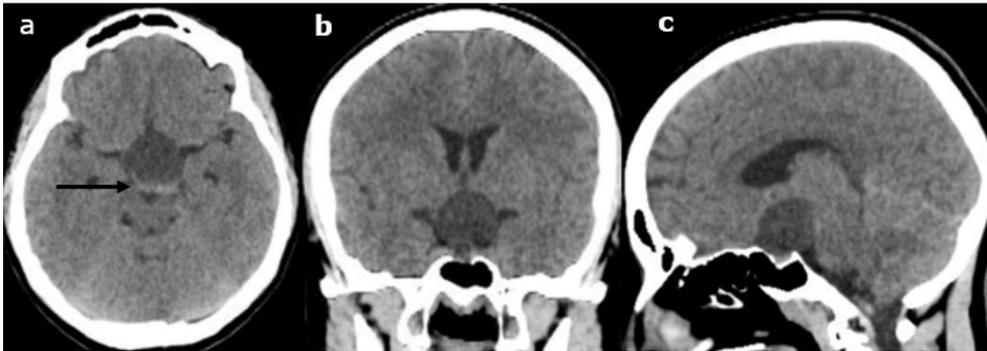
Computed tomography of the skull in axial (a), coronal (b) and sagittal (c) views. There is evidence of sellar mass reappearance and apparent hyperdensity that may indicate rebleeding of the lesion (arrow).
